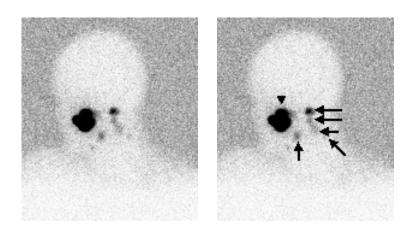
Image of malignant melanoma on lymphoscintigraphy.
